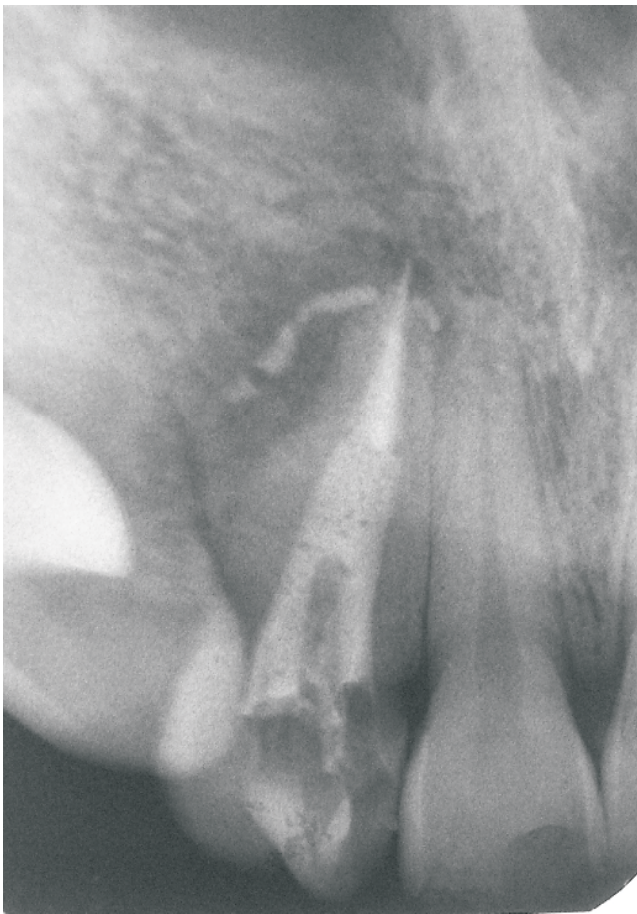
Immediate post obturation radiograph showing apically extruded obturation material.
